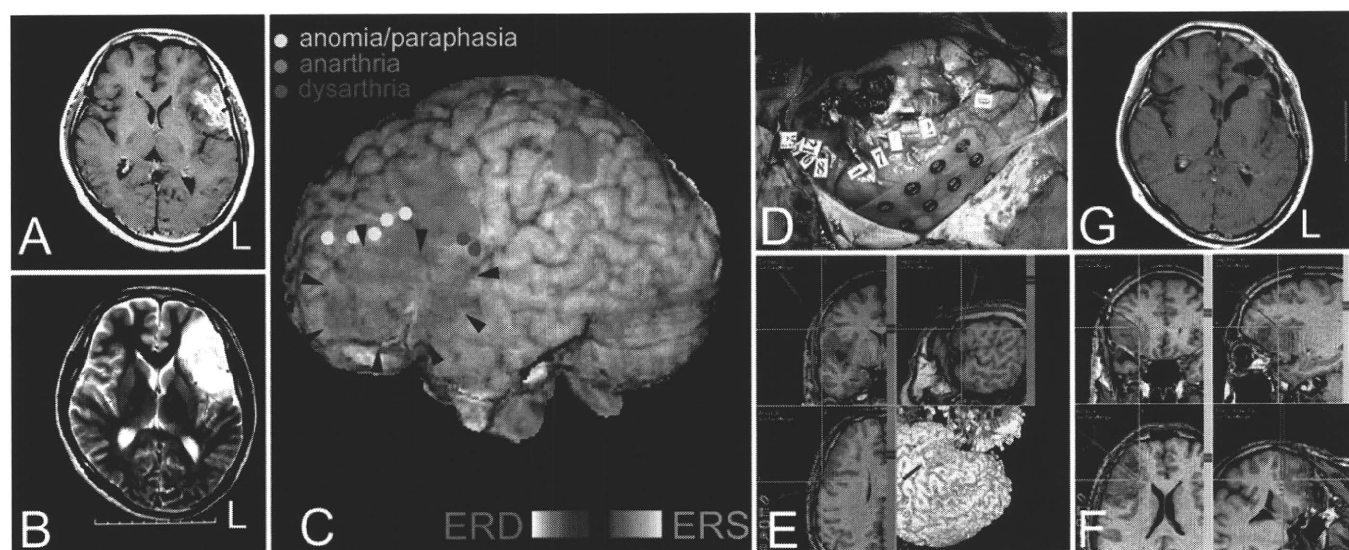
Case 6. Images obtained in a patient with anaplastic oligoastrocytoma in the Broca area. A: Preoperative Gd-enhanced T1-weighted MR image revealing a heterogeneously enhanced large tumor in the left inferior frontal gyrus. B: Preoperative T2-weighted MR image showing most of the inferior frontal gyrus occupied by the tumor. C: An MEG image showing language localization superimposed on the patient's MR image. *Black arrowheads* indicate the tumor boundary. Stimulation-positive sites, indicated by the *colored dots*, were also superimposed on the MR image. *Magenta areas* indicate statistically significant ERD detected on MEG; *yellow areas* indicate statistically significant ERS detected on MEG. A p value < 0.001 was considered statistically significant. D: Photograph showing electrical cortical stimulation during awake surgery. Subdural electrodes were placed to monitor after-discharge. *Numbered papers* indicate stimulation-positive sites. E: Navigation display during stimulation mapping demonstrating a navigation probe pointing to a stimulation-positive site. F: Navigation display during tumor removal showing a navigation probe pointing to the deepest tumor boundary portion. G: Postoperative MR image showing no apparent enhanced mass lesion.
